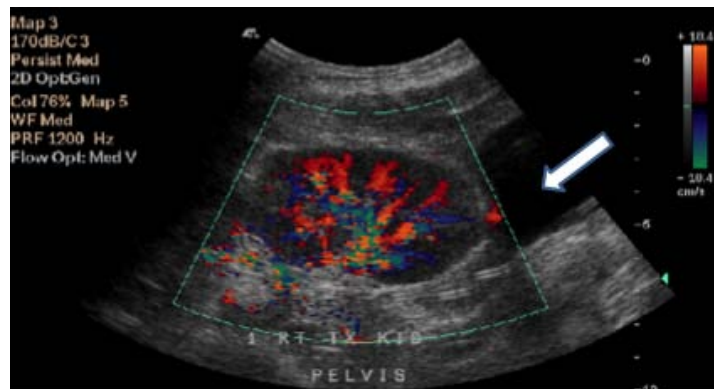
En-bloc kidneys on ultrasound scan.
